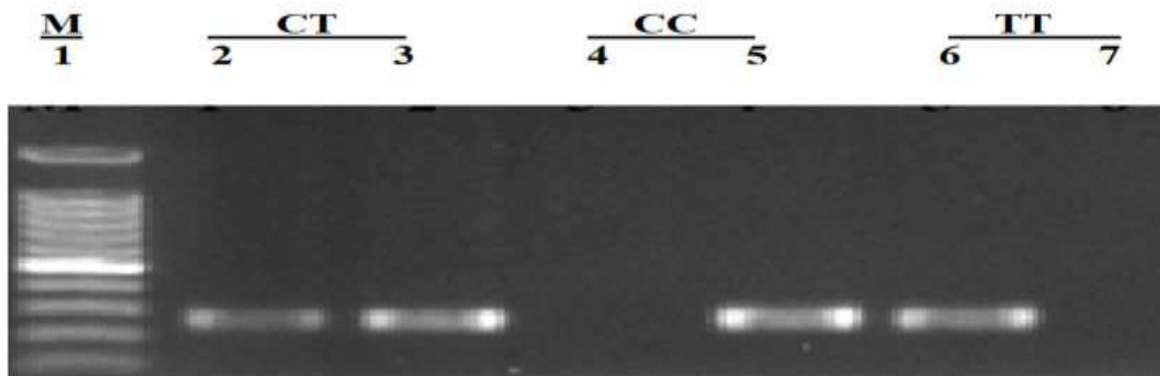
Genotype distribution of IL-10 -819C/T (rs3021097) genotypes' distribution in HCV infected patients and healthy controls by using allele-specific (AS) PCR. Experimental conditions were similar to those described in Figure 1. The 233 bp represents the amplification of IL-10-819C/T variants. Lanes order: lanes 1- 2, CT; lanes 3-4, CC; lanes 5-6, TT genotype and lane M; 100 bp DNA marker
